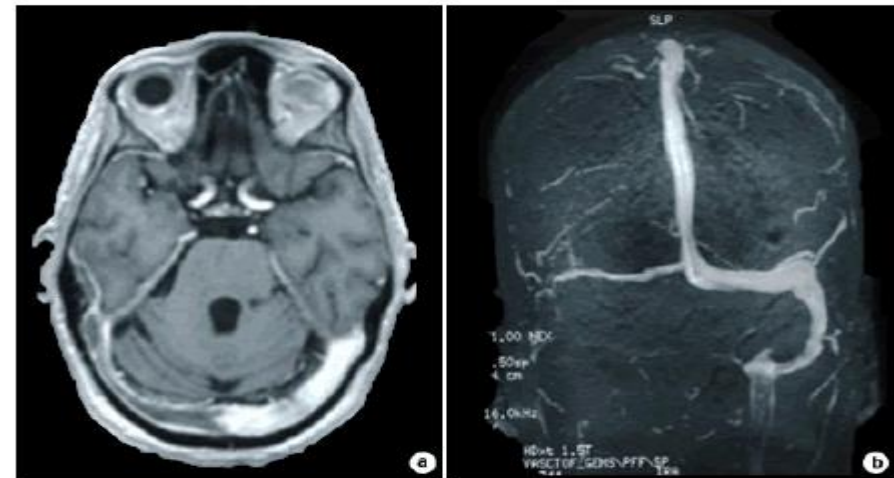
T1 weighted brain MRI after gadolinium injection (a) and MR angiography (b) showing right lateral sinus thrombosis and enhancement of the meninges.
